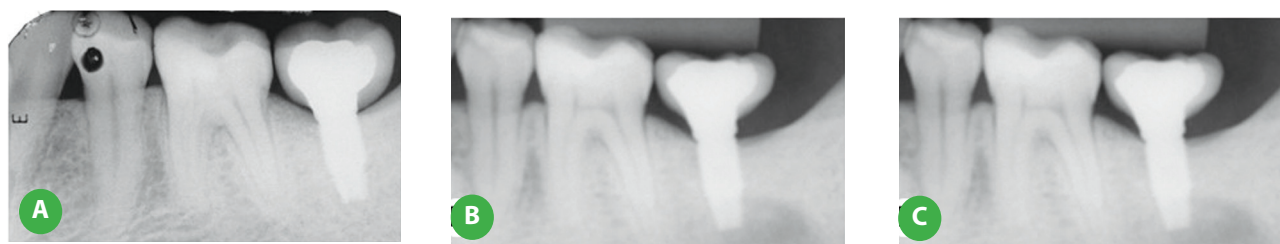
Radiographic image after prosthetic rehabilitation, 6 months after implant placement with the bone granulation tissue technique (A). After 4 months, a new crown was made due to a fracture of the previous one (B). Five-year follow-up after implant placement, indicating the maintenance of surrounding bone (C).
